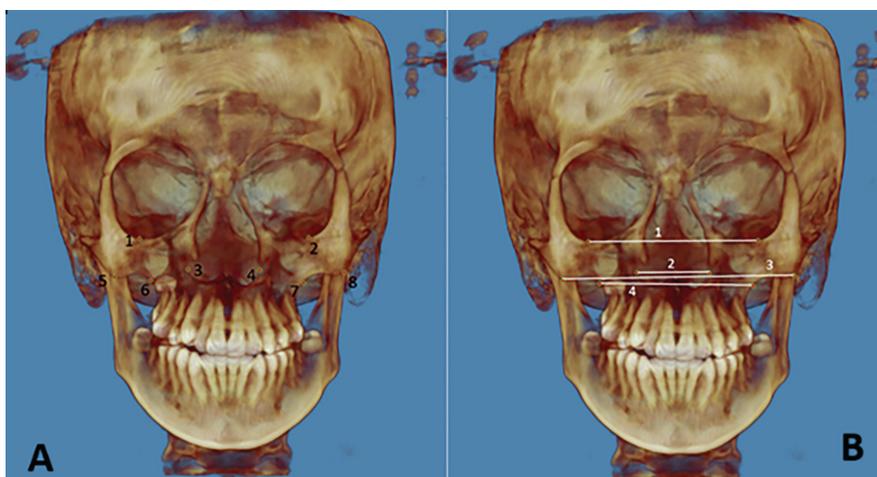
CBCT frontal reference points and skeletal transverse measurements. (A) Reference points: 1. right orbital point; 2. left orbital point; 3. right nasal point; 4. left nasal point; 5. right zygomatic point; 6. right maxillary point; 7. left maxillary point; 8. left zygomatic point (B) Linear measurements: OrR-OrL (The distance between the right and left orbital) 2) NcR-NcL [The distance between the right and left nasal (Nc) points] 3) ZygR-ZygL (The distance between the right and left zygomatic (Zyg) points) 4) MxR-MxL (The distance between the right and left maxillary (Mx) points). CBCT, cone-beam computed tomography.
